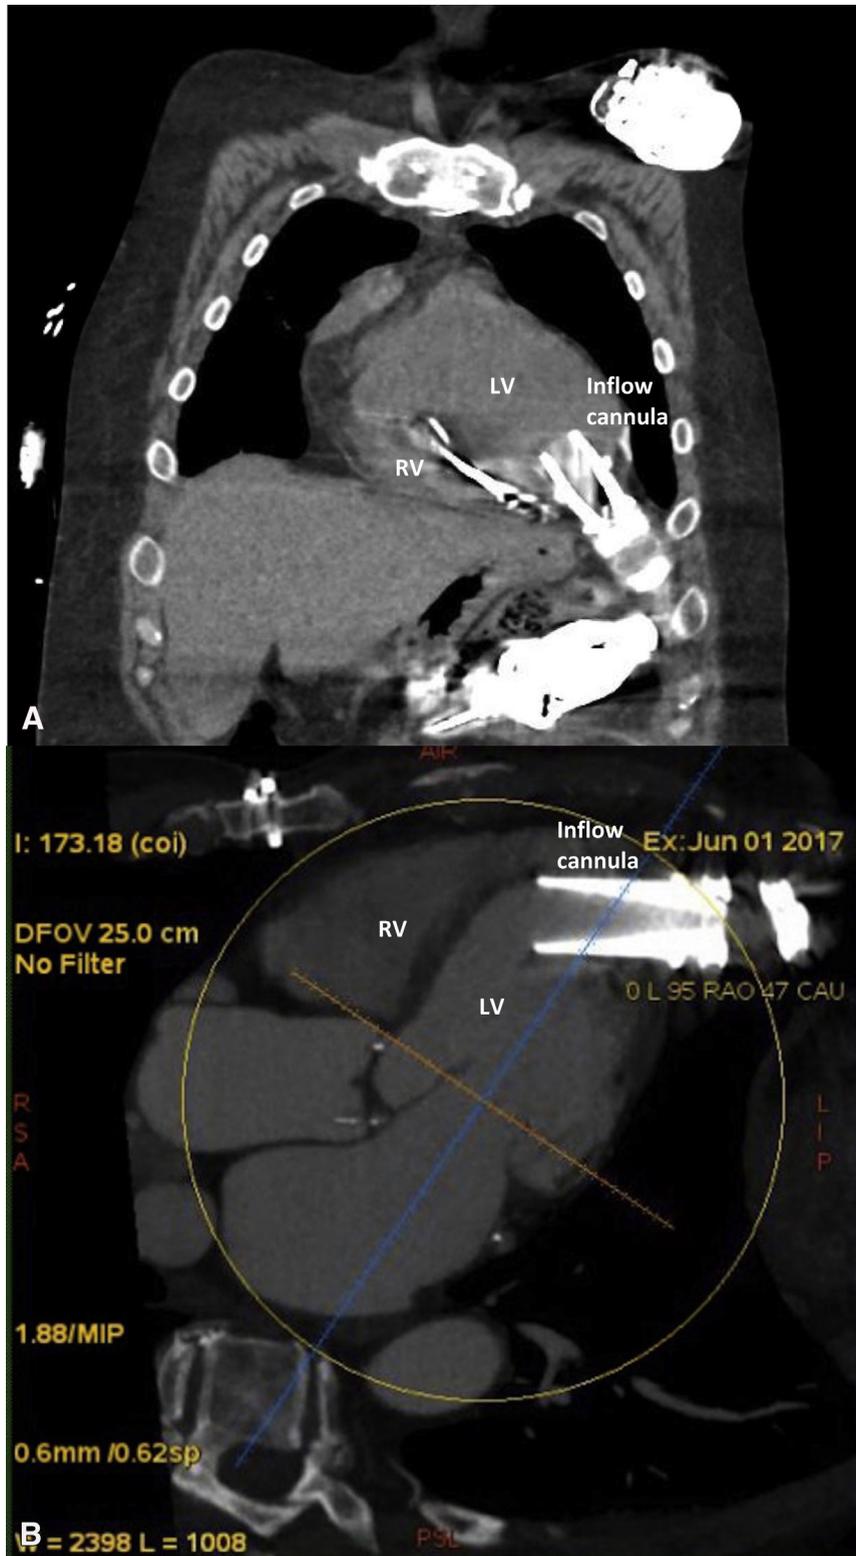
Cardiac computed tomography showing an appropriately positioned left ventricular assist device inflow cannula (A) compared with the malposition of the inflow cannula against the interventricular septum in the case patient (B). RV = right ventricle; LV = left ventricle.
